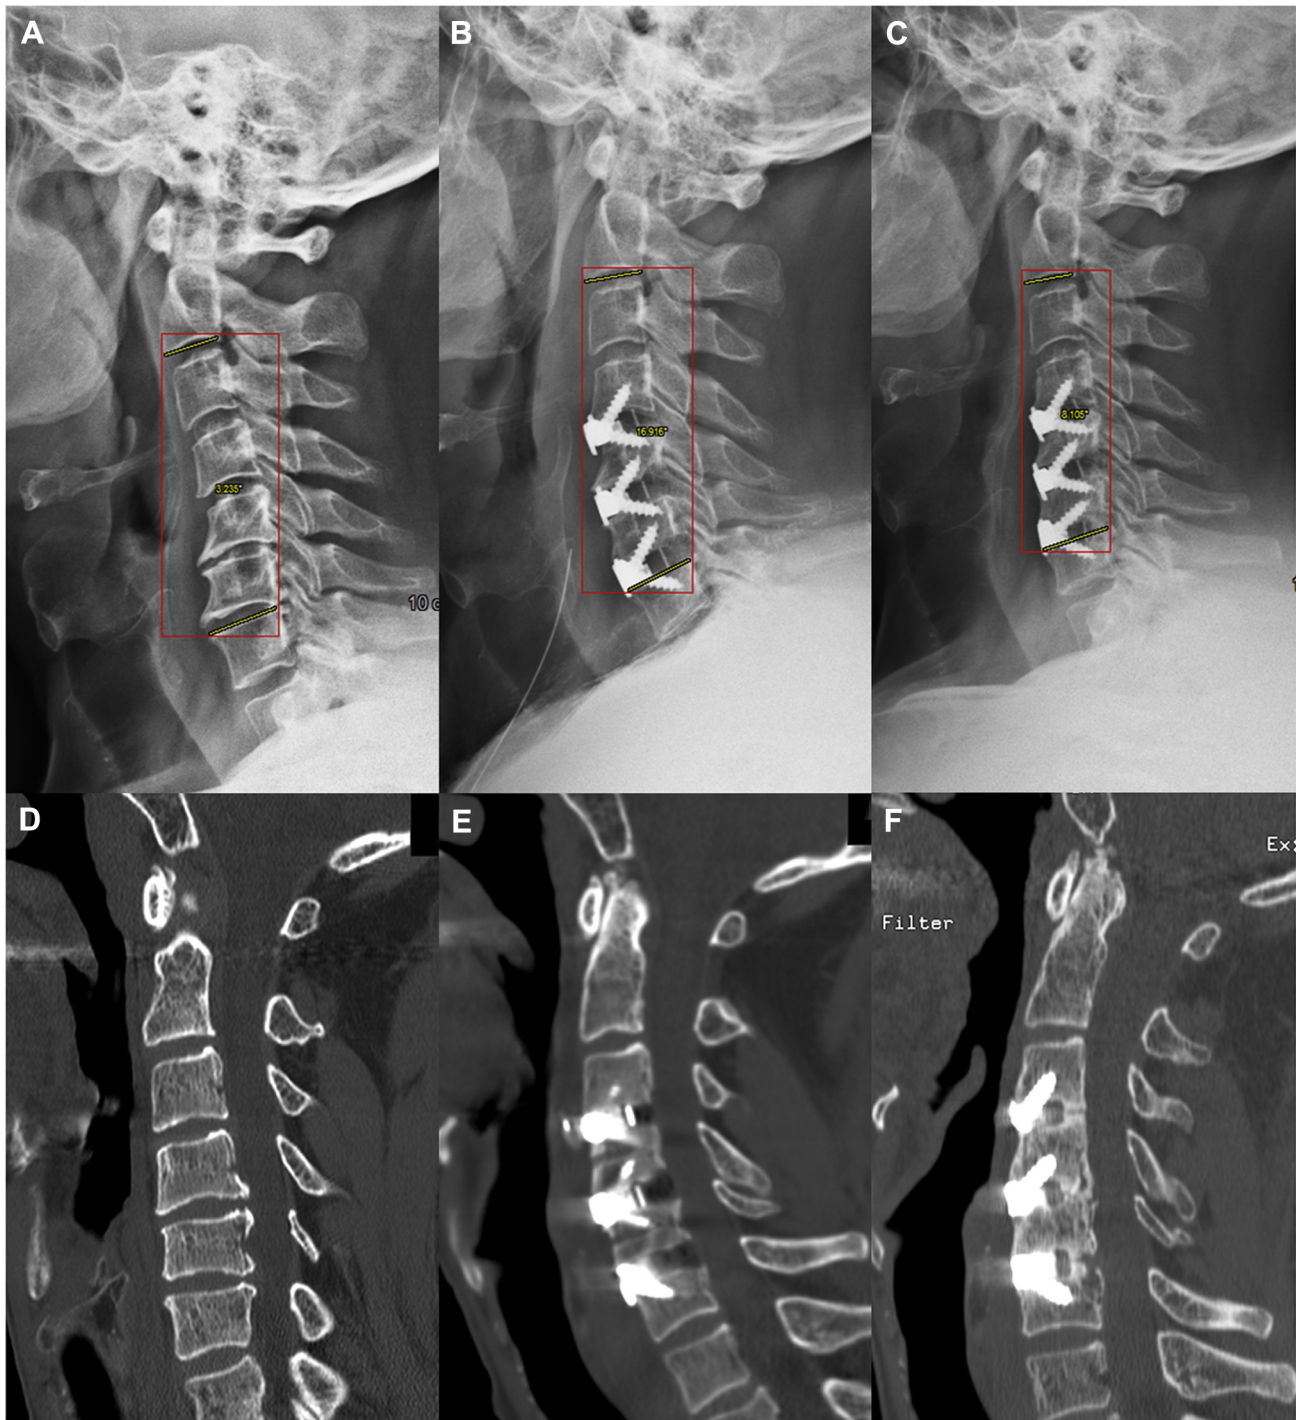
Comparison between preoperative (A), early postoperative (B), and last follow-up (C) lateral radiographs documents the changes in sagittal alignment measured according to Cobb's method. Evaluation of preoperative and postoperative sagittal reconstructed computed
